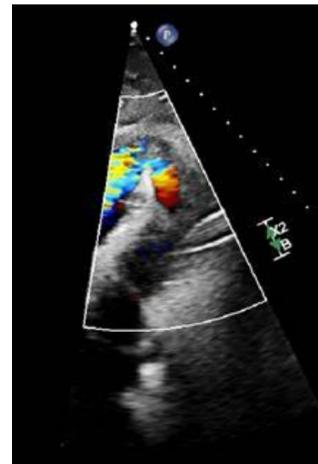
Transthoracic ECHO demonstrating VSD
